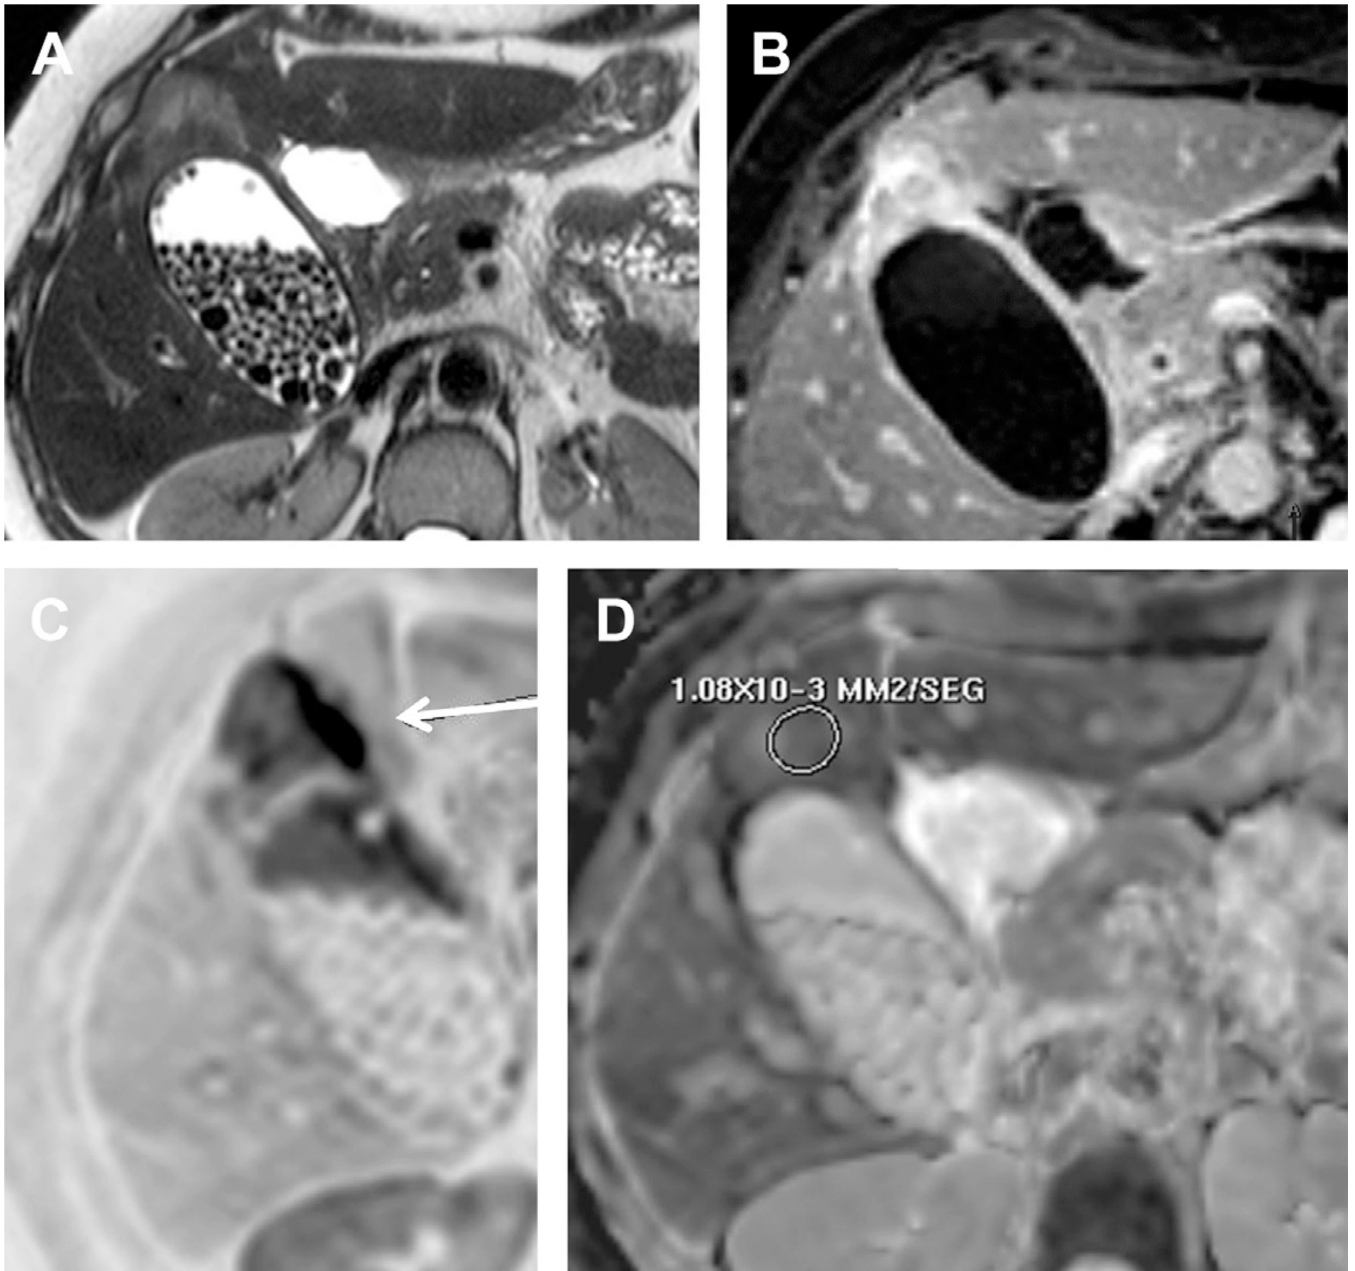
Gallbladder carcinoma with DWI. (A) Axial TSE T2-weighted image and (B) delayed postcontrast T1 high resolution isotropic volume excitation (THRIVE) show a mural thickening of the fundus of the gallbladder invading the adjacent hepatic parenchyma. Notice the presence of multiple lithiasis. (C, D) High b-value DWI with inverted gray-scale and corresponding ADC map demonstrates restriction of water motion of the mural lesion (arrow), with low ADC of $1.08 \times 10^{-3} \text{ mm}^2/\text{s}$ (ROI).
